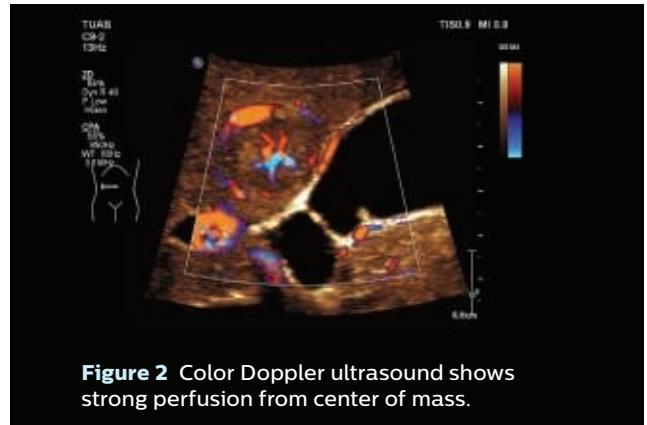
Color Doppler ultrasound shows strong perfusion from center of mass.
